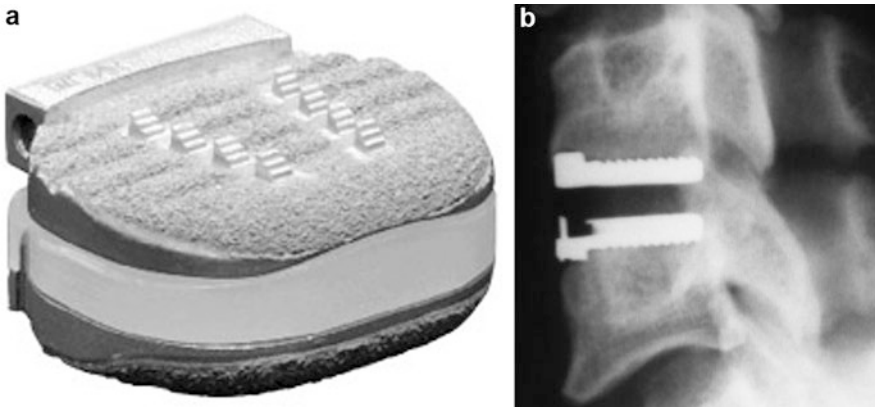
Porous coated motion prosthesis: (a) device; (b) lateral X-ray after implantation
